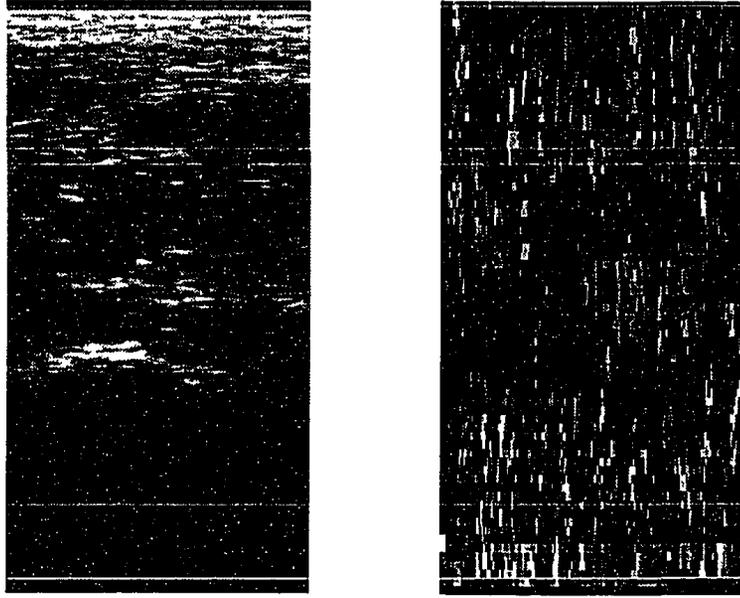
Transverse ultrasound and strain images of Achilles' tendon.
